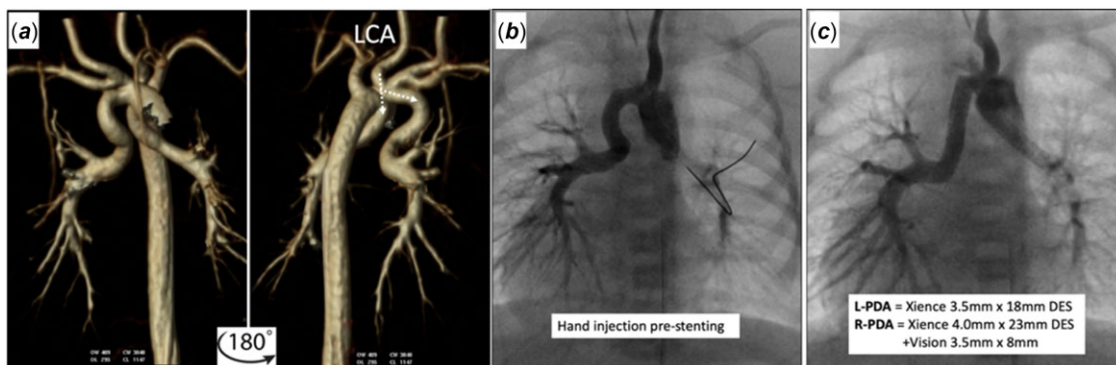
Neonate with discontinuous pulmonary arteries and bilateral PDAs. (a) Pre-procedural cardiac CT 3D reconstruction shows the left carotid artery (LCA) as the best approach to stent both PDAs via one access site. (b and c) Both PDAs are stented via the LCA. One stent [Xience 3.5 mm × 18 mm drug eluting stent (DES)] was placed in the left PDA and two stents were placed in the right PDA (Xience 3.5 mm × 18 mm DES × 1 and 3.5 mm × 8 mm Vision Multilink stent × 1).
